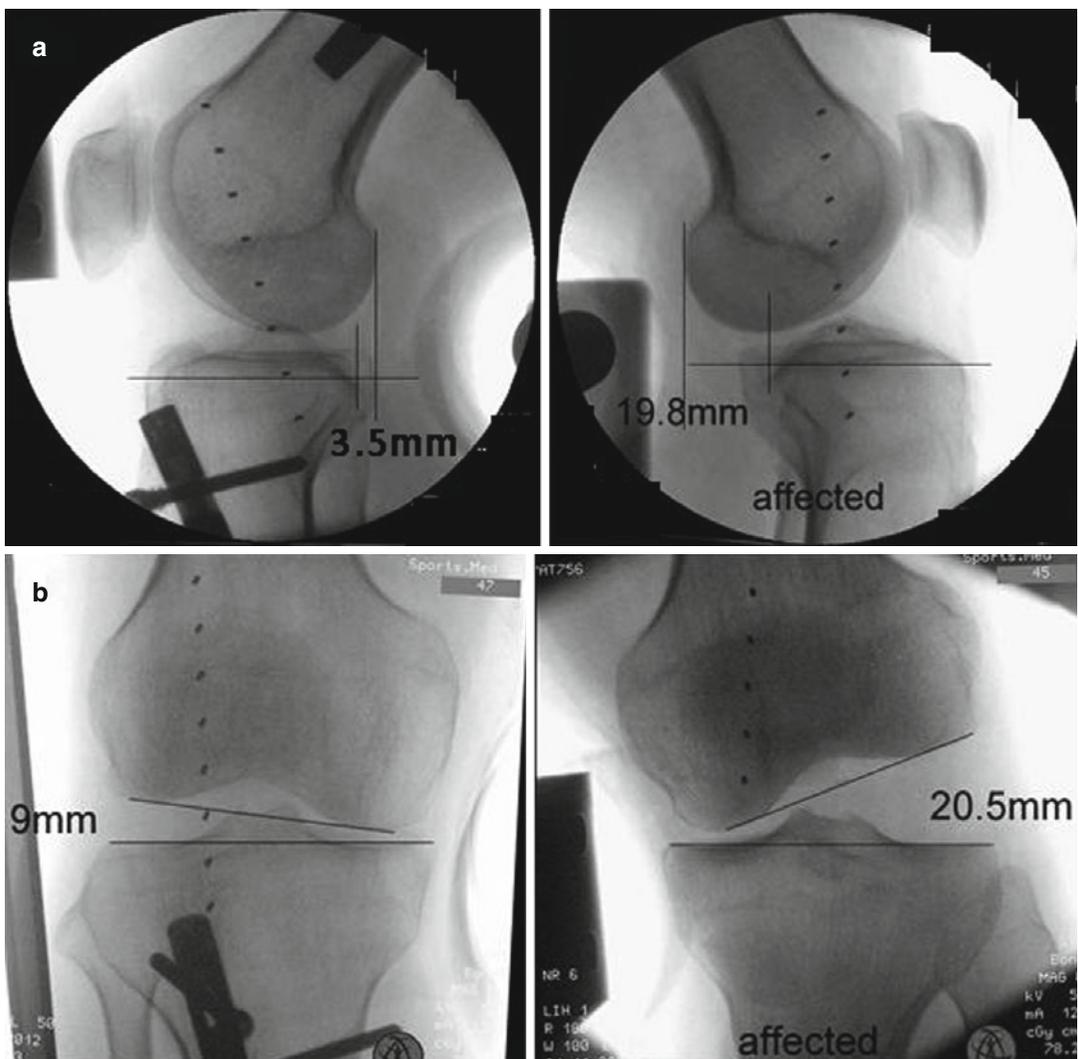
The Telos stress radiography performed on a patient suspected with multi-ligamentous injuries. The side-to-side differences of (a) anterior tibial displacement
